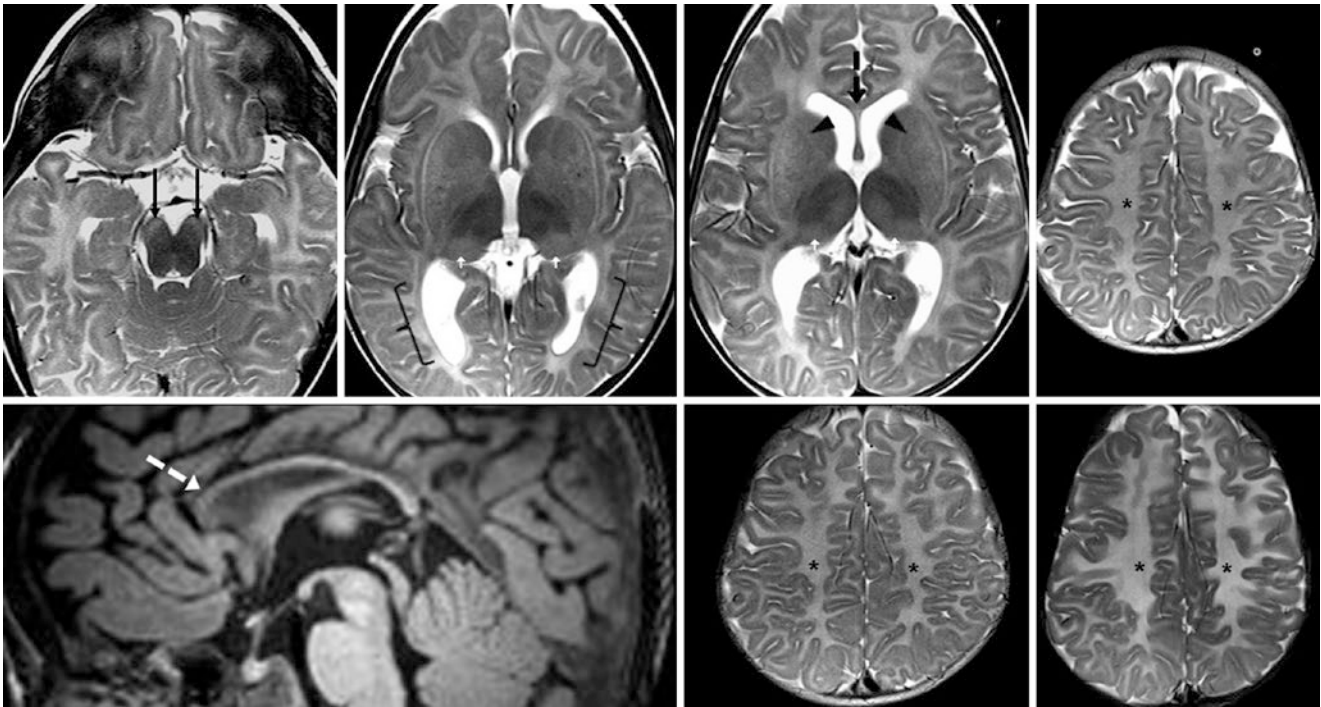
Comparison case of GM2 gangliosidosis (Sandhoff's disease). In a 10-month-old, a 3T MRI showed diffusely poor myelination on SE T2WIs (top row), with a severely thin corpus callosum on sagittal T1WI (bottom left). Note failed myelination of the ALIC (arrowheads), CG (dashed arrows), optic radiations (brackets), and corona radiata
